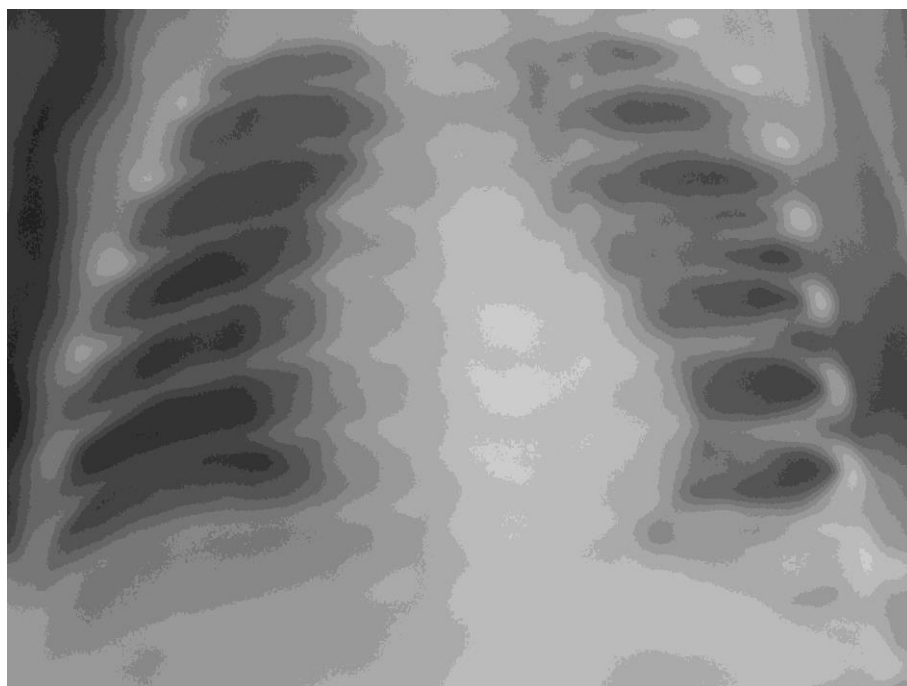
Radiograph of child A. at discharge, 14 days. Gestation period 33 weeks. Residual effects after atelectatic pneumonia. Airy lung fields. Nodose-reticular mesh in the root zones. Enlarged cardiac shadow.
